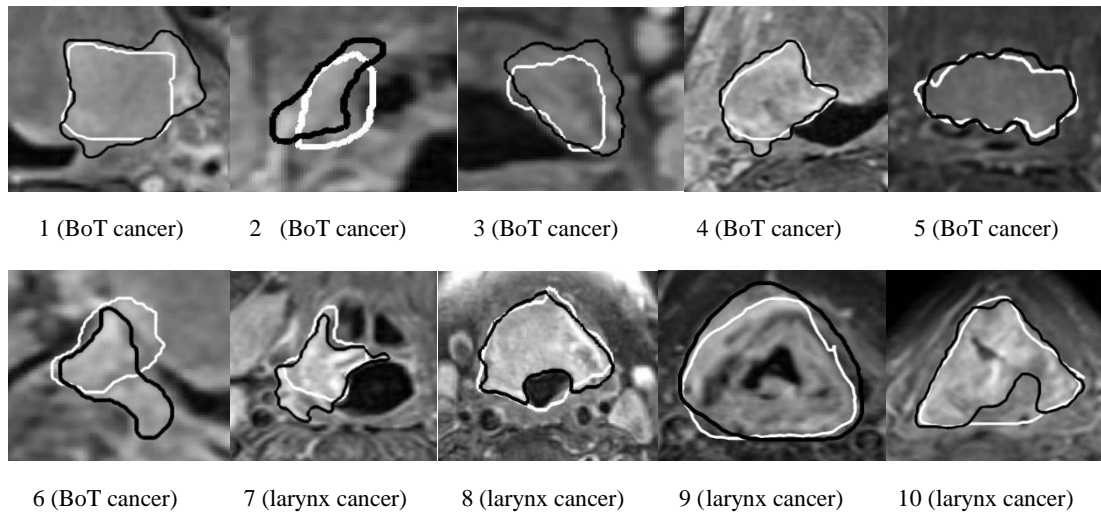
Examples of C-auto (PLCSF) (black outline) on small tumour regions or challenging cases, superimposed with the C-gold (white outline) from real MRI dataset (Table 4.1 and Fig.
